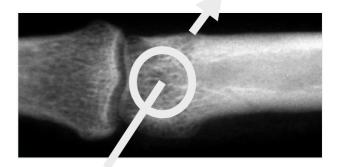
Direction of ultrasound beam penetration through the distal epiphysis of human finger phalanges (dorso-volar).
